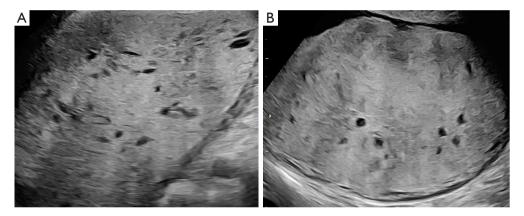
Case 2. Ultrasound image at 26 weeks of pregnancy with PMD. (A,B) The placenta exhibits diffuse thickening, with abnormal echoes present within. The affected area encompasses the entrance of the umbilical cord into the placenta. PMD, placental mesenchymal dysplasia.
